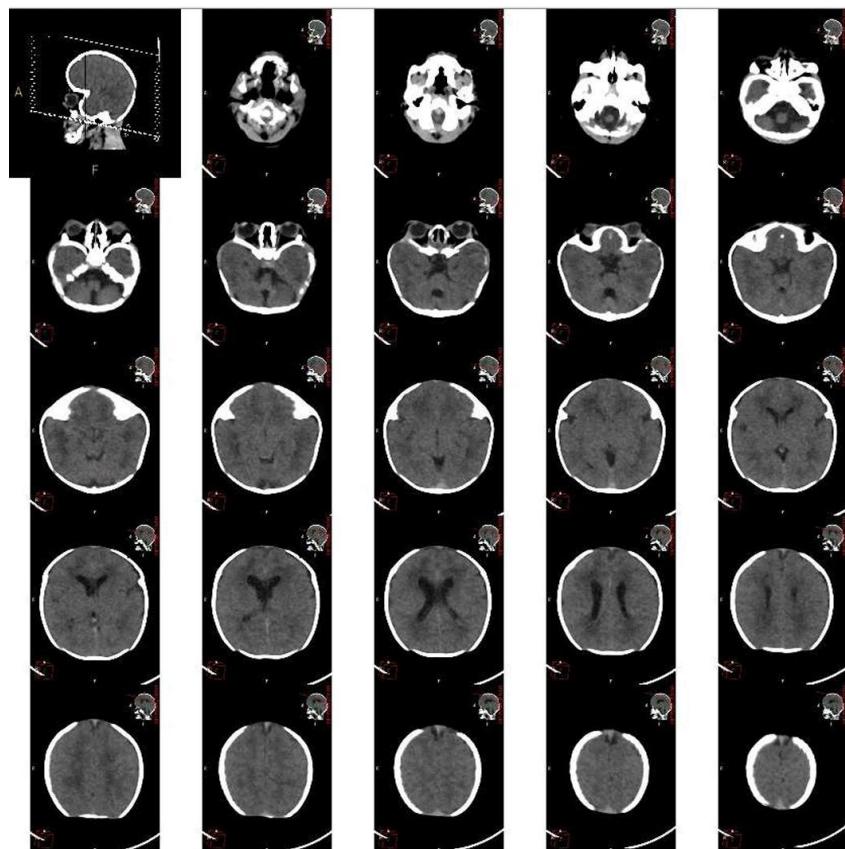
A non-contrast head CT scan
